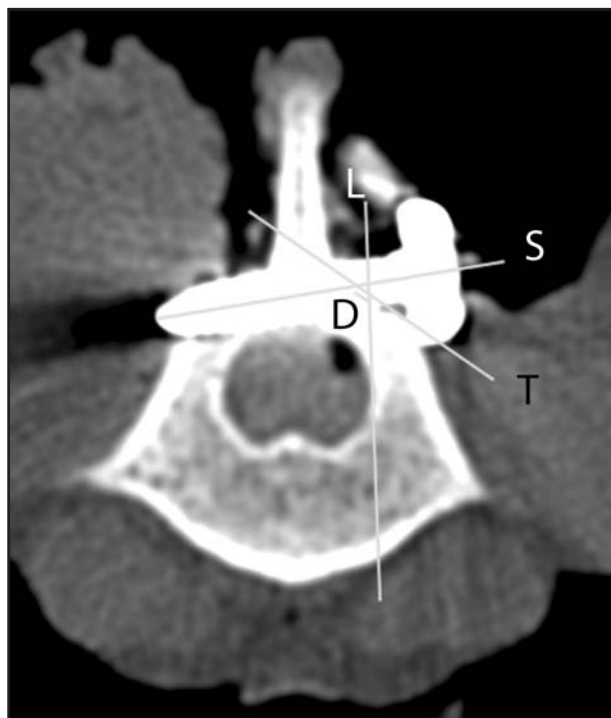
A CT image depicting the association between the preoperatively determined POI and the actual point at which the screw was inserted. The distance (line D) is measured from the center of the screw (line S) to the POI, which is found with line L along a tangential line (line T) representing the laminar discortex. The length of line D was 800 μ m.
